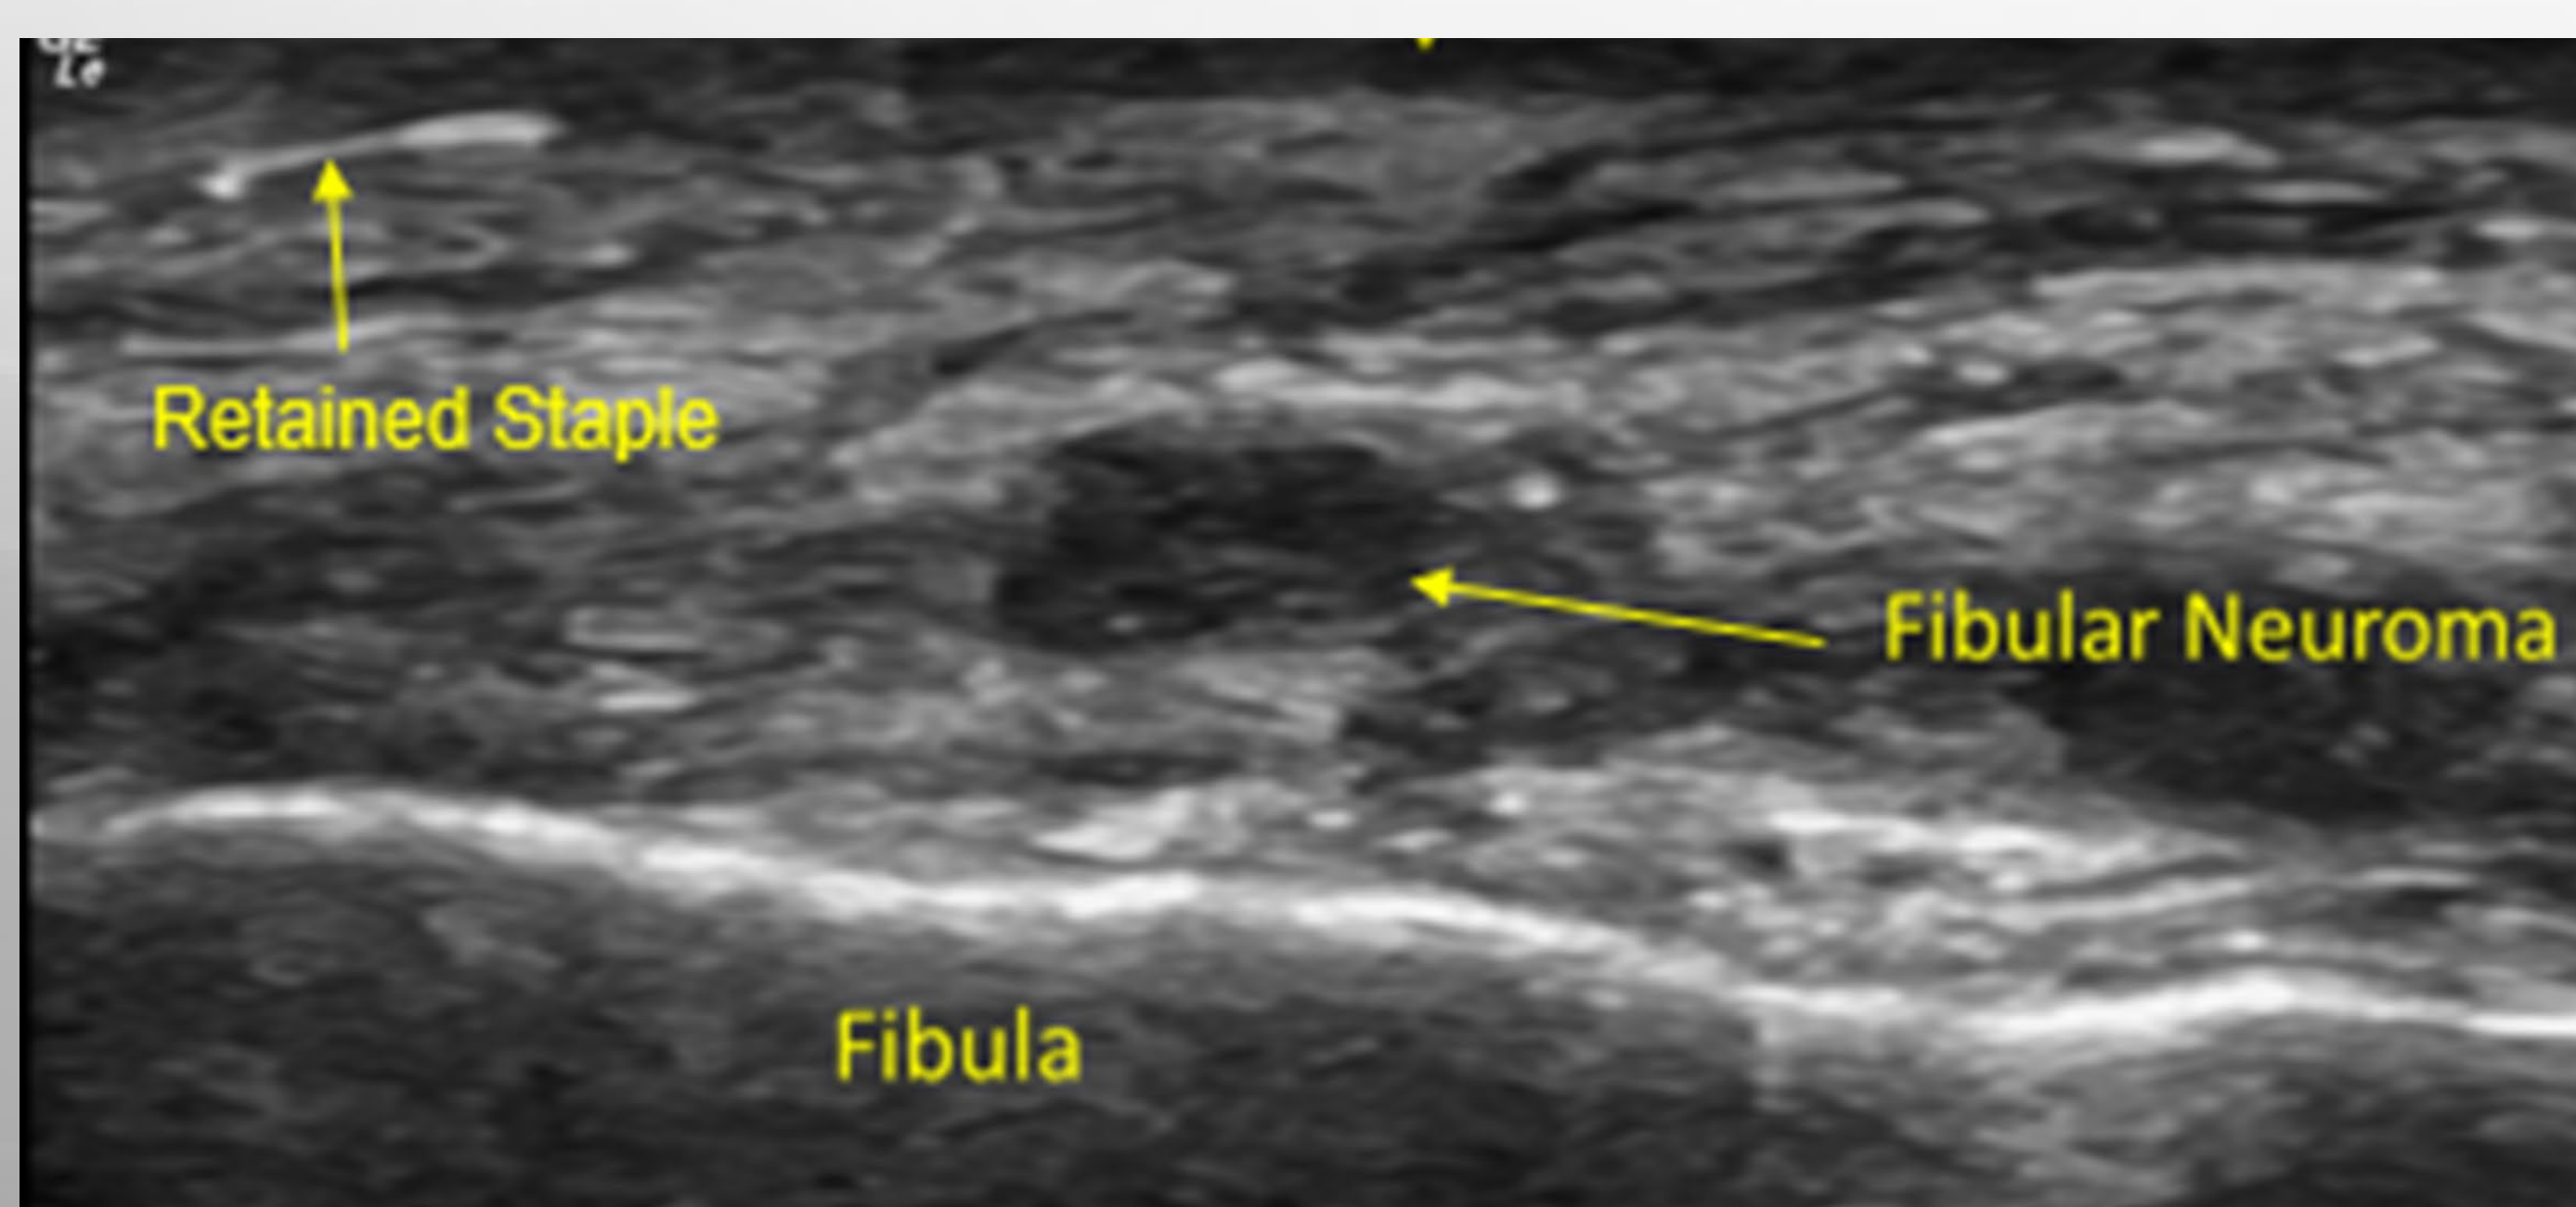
Ultrasound imaging of distal fibular neuroma
